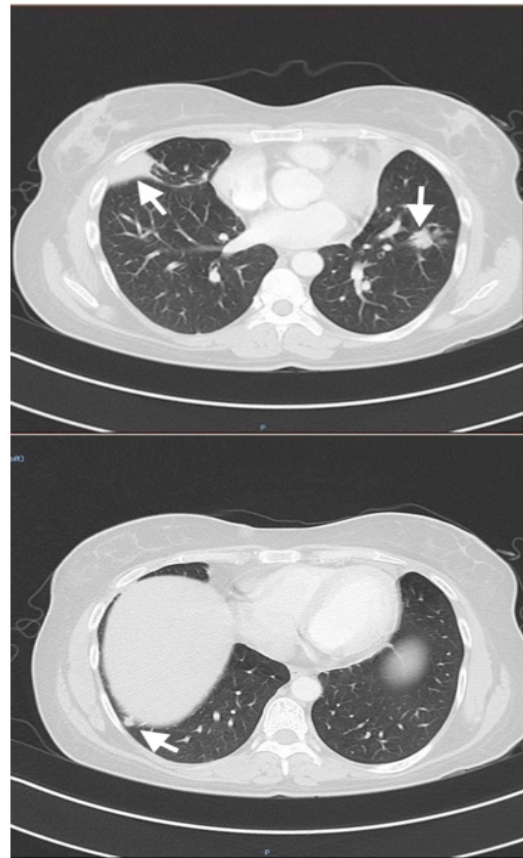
a, b: CT showing multiple nodules over both lung bases (white arrows).
